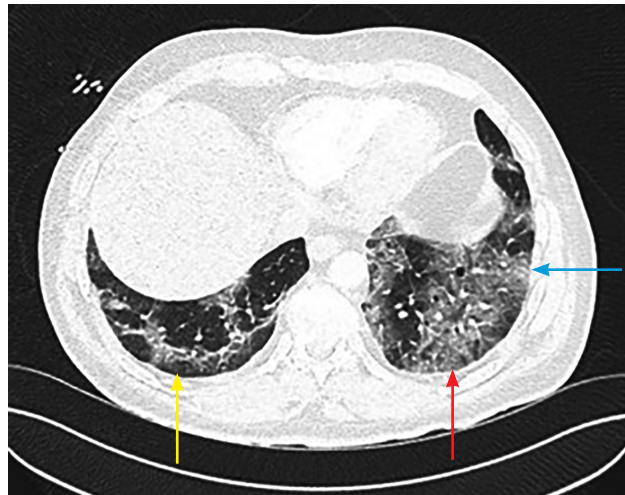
Computed tomography image demonstrating multiple alveolar opacities associated with consolidation (blue arrow), ground-glass change (red arrow) and peri-lobular abnormalities (yellow arrow).
